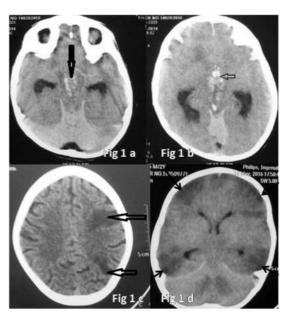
(A and B) Axial section of plain cerebral CT scan shows hyperdensities in the midbrain (arrow in Fig. 1A) and along internal cerebral veins (arrow in Fig. 1B) due to haemorrhage and thrombosis. (C) Axial section of plain cerebral CT scan shows hypodensities in high frontal and posterior parietal region (arrows) on left side due to infarction. (D) Axial section of plain cerebral CT scan showing multifocal infarcts (arrows) involving cortical and subcortical regions of the frontal and temporal lobes.
